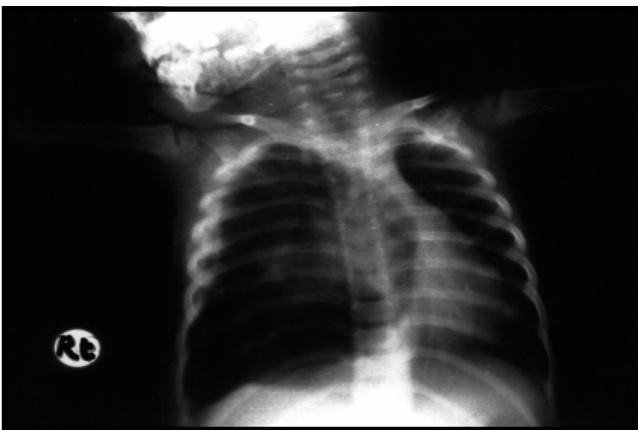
Chest x-ray of a child showing tension pneumothorax due to inhalation of a spike of wild barley.
